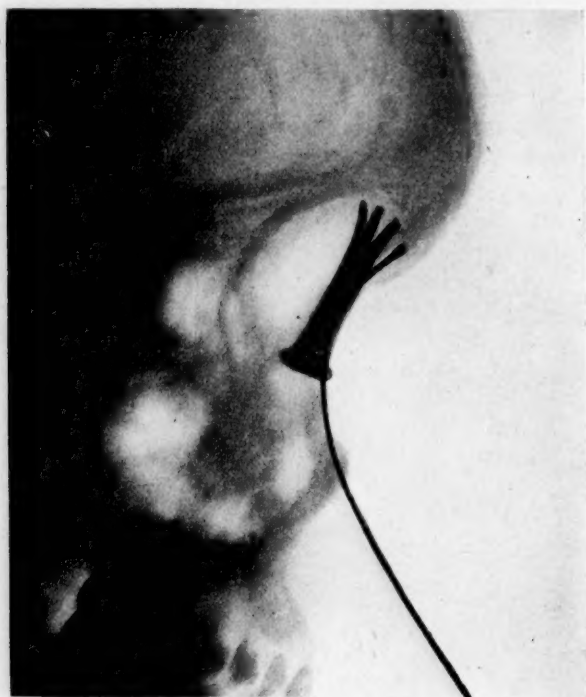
From retouched negative lateral view taken from the same patient at the same time as Figure VIII. In this exposure the probe did not show distinctly in the radiograph where it was overlying the drainage tube, but the shadow was faintly traced.
